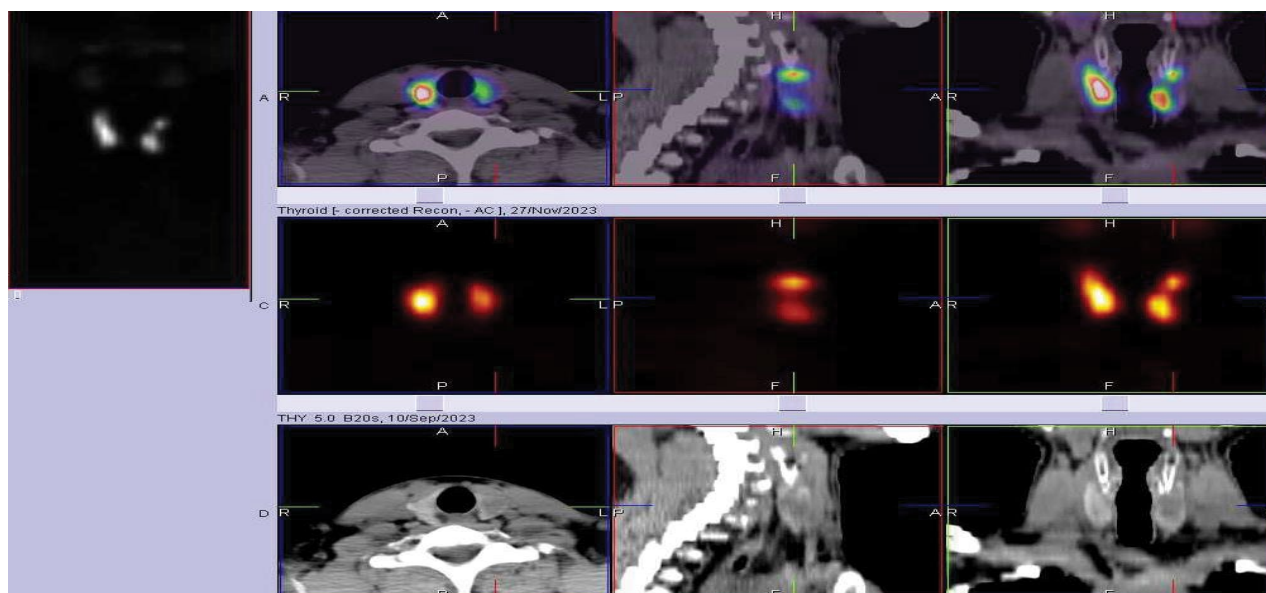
Technetium uptake scintigraphy scan revealed it to be a cold nodule.
